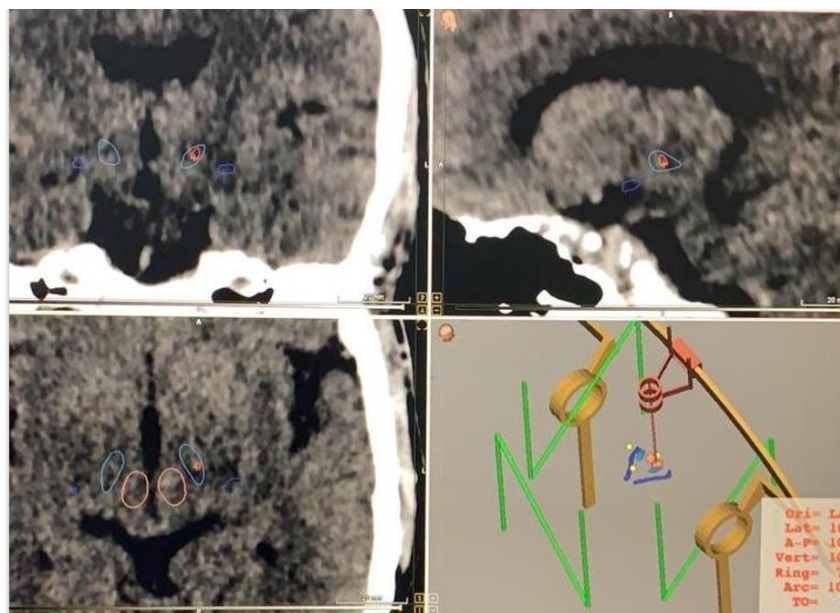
Postop CT showing Subthalamic Lesion
